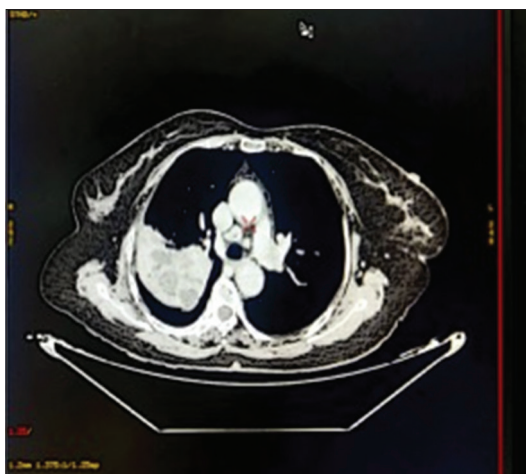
Contrast-enhanced computed tomography thorax of the patient
